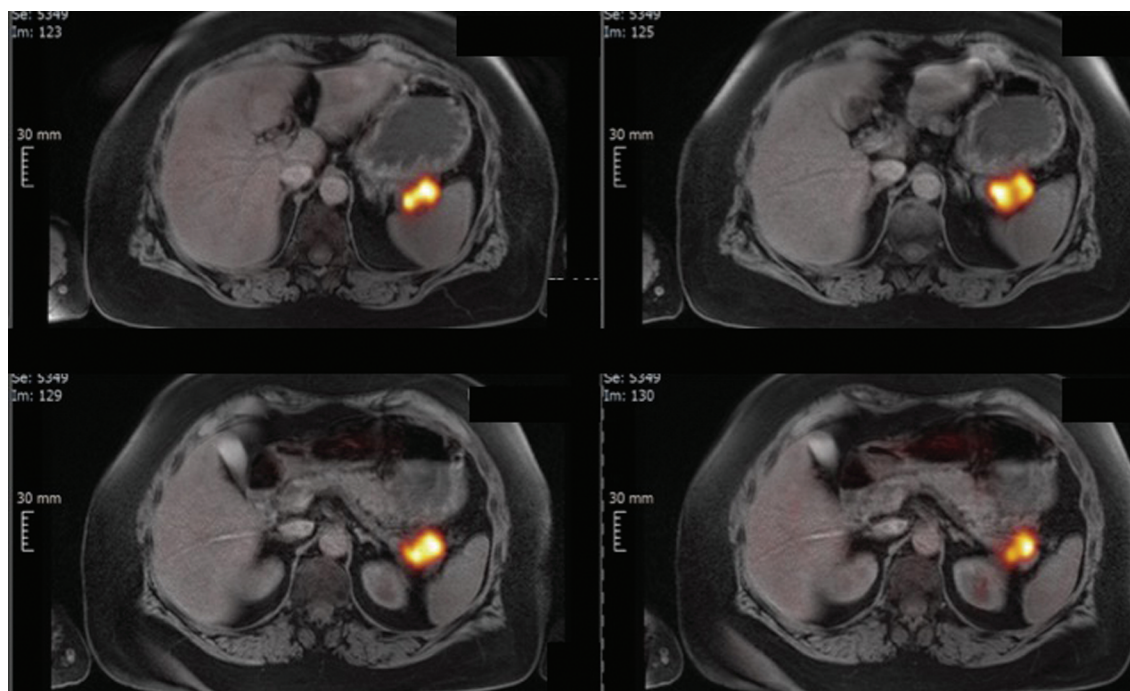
Positron emission tomography–computed tomography (PET-CT) confirmed a neoplastic lesion in the left upper quadrant.
